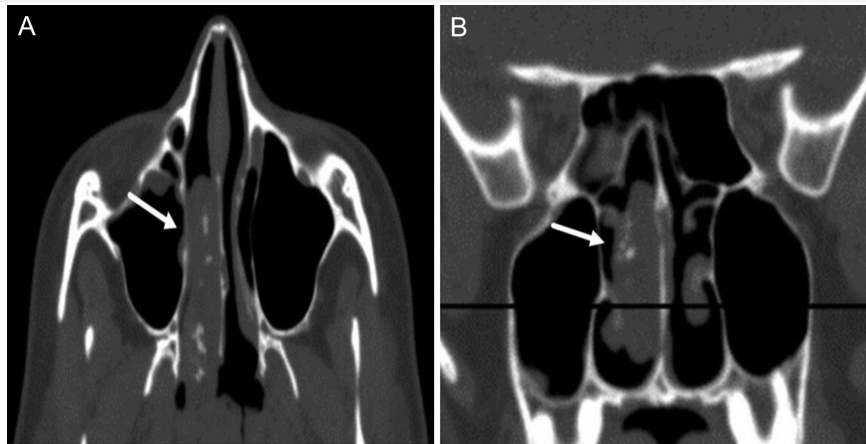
A, B. Computed tomography of the nose and paranasal sinuses in axial (A) and coronal (B) projections. The arrow indicates the mass.
